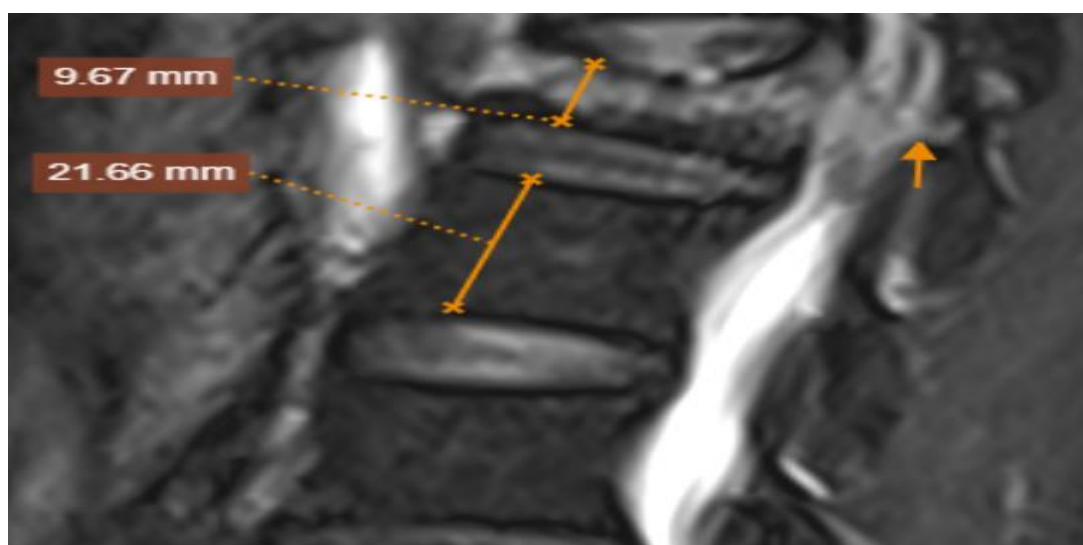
MRI-Based L1 Injury Classification by TLICS, TL AOSIS, and mTLICS
